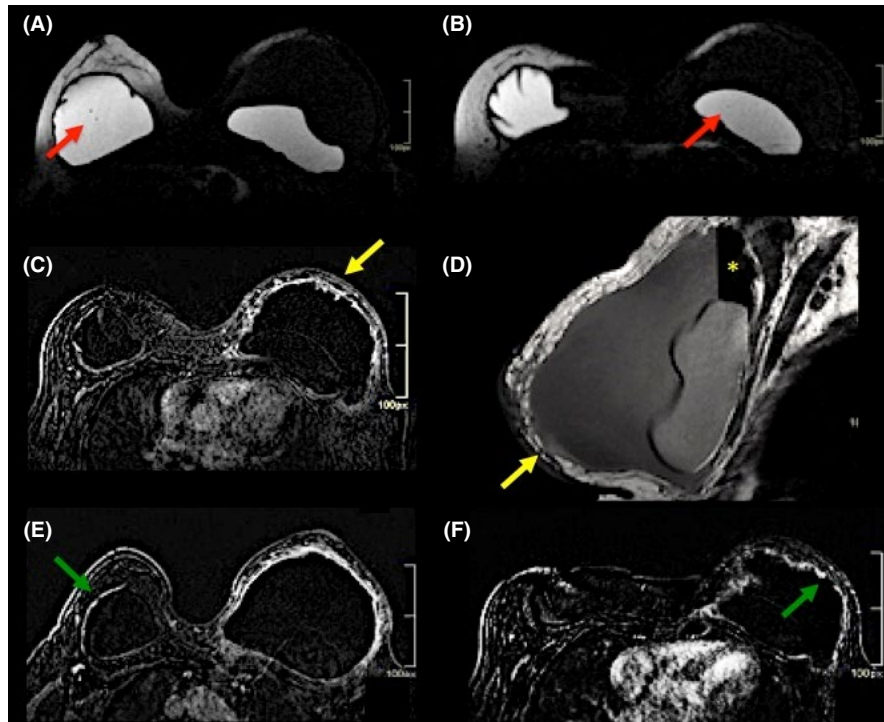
Breast magnetic resonance imaging. A and B, Axial T2-weighted faspin-echo water-suppressed: “water droplets” (red arrow) suggesting an alteration in implant permeability. C, Axial dynamic contrast enhancement: the thickening of the fibrous capsule and intracapsular mass both with delayed contrast enhancement, indicating an inflammatory capsular process (yellow arrow). D, Sagittal proton density-weighted: the thickening of the fibrous capsule (yellow arrow) and hydro-aerial level (yellow asterisk). E and F, Axial dynamic contrast enhancement: bilateral “black drop sign” (green arrow) radiologically representing the silicone gel bleeding into the fibrous capsule
